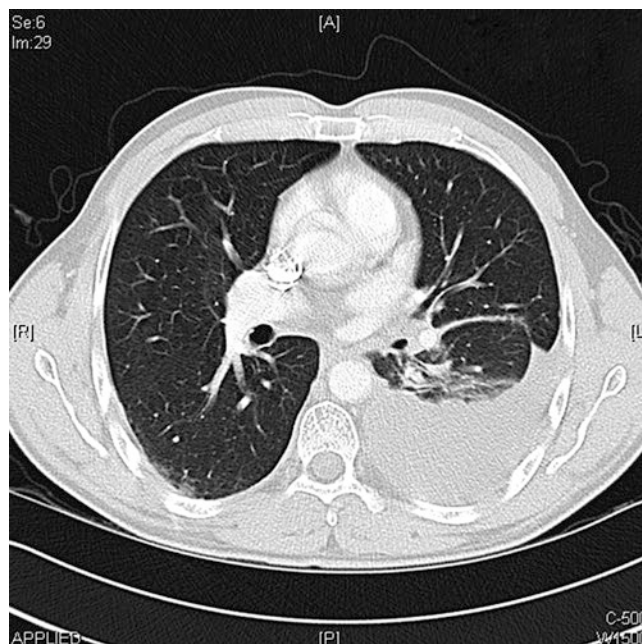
CT—early disease—simple pleural effusion
